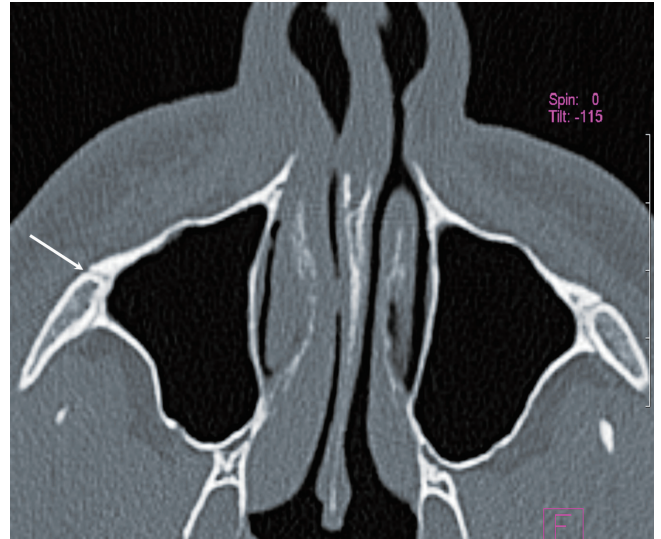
Sutura zygomaticomaxillaris (arrow), axial CT.
